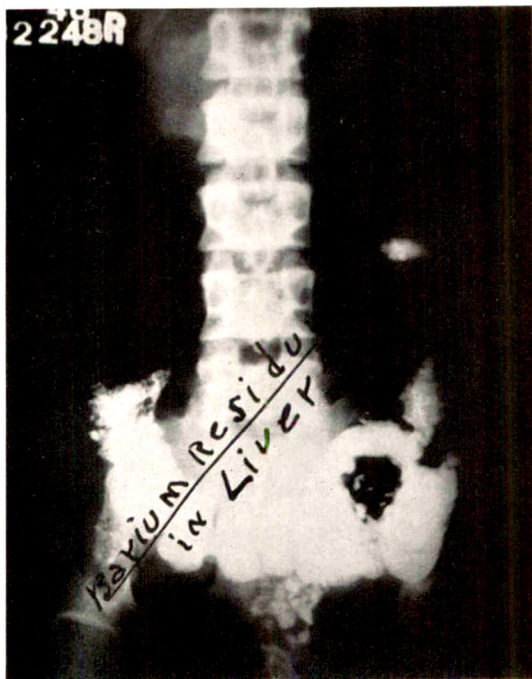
Roentgenogram shows an island of barium in the liver.
